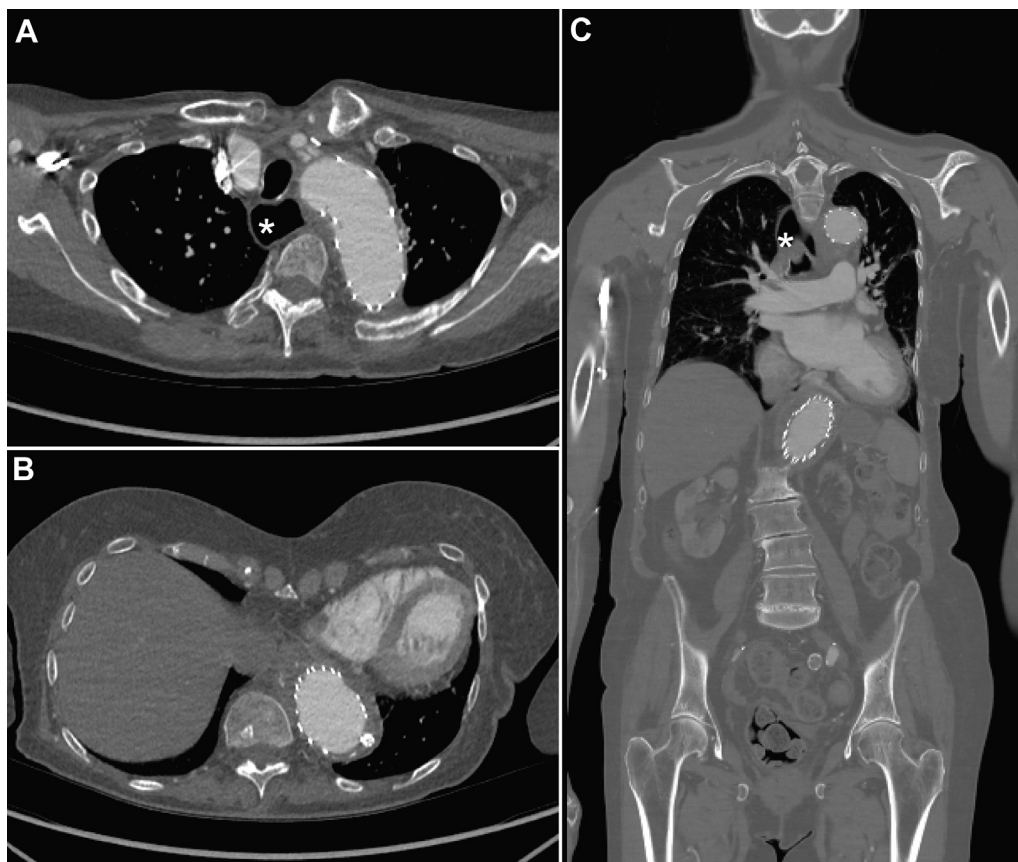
Postoperative computed tomography (CT) angiography after thoracic endovascular aortic repair (TEVAR) for thoracoabdominal aneurysm demonstrating decreased aneurysm size and resolution of esophageal dilation. Axial view in aortic arch (A) and diaphragm (B) and coronal view (C). The esophagus is marked with an asterisk.
